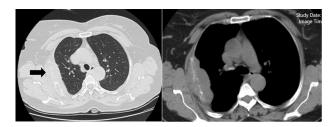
Spiral chest CT: sub plural soft tissue mass with rib destruction. *Note.* CT: Computed tomography.
